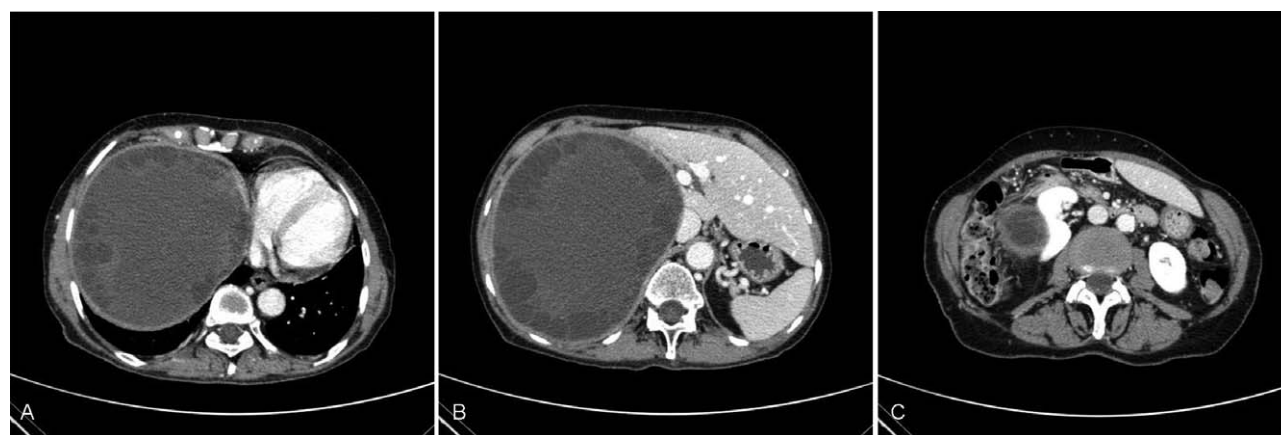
CT scan of a 75-year-old woman with a giant hydatid cyst measuring 25 cm in its major diameter containing daughter cysts, and causing mediastinal shift with displacement of the heart, inferior vena cava, stomach, and right kidney (A–C). To note, there was a compensatory hypertrophy of the left hepatic lobe (B). Operation performed: Right hepatectomy with diaphragm repair.
